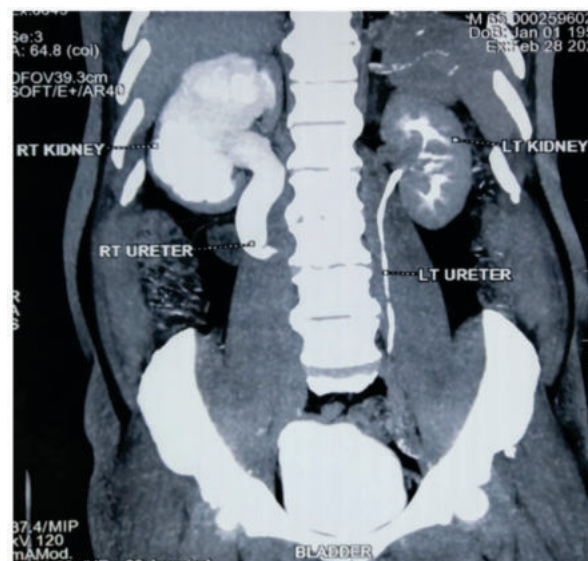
CT urogram showing right retrocaval ureter.
